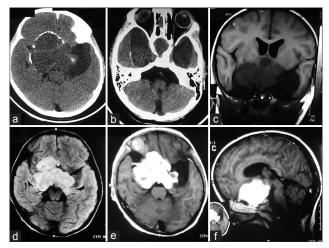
(a and b) Computed tomography scan showing iso-hyodense suprasellar mass with parasellar extension with expansion of skull base and rim calcification; (c) Coronal magnetic resonance imaging showing the bilateral parasellar extent of lesion; (d) Axial proton-density magnetic resonance imaging showing uniform lesion with increase intensity; (e and f) Axial and sagittal magnetic resonance imaging showing the brilliant and homogenous enhancement of lesion
